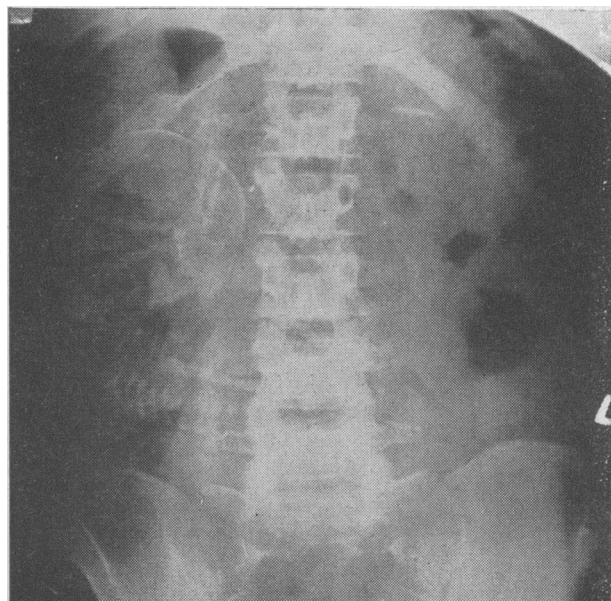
A.-P. radiograph of extrauterine pregnancy at 30 weeks (Case 4). This shows the odd foetal attitude and the presence of gas shadows over the upper chest of the foetus. The back is downward—an exception to Snow's rule.
